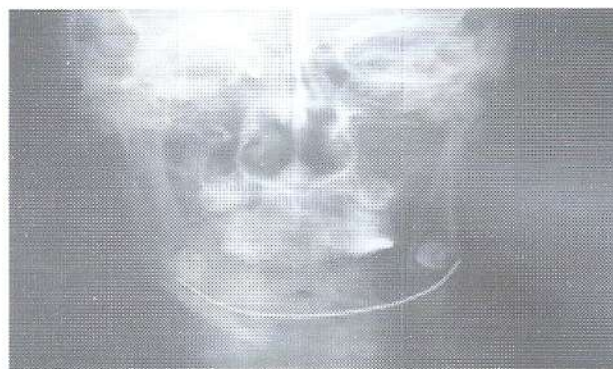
PA radiograph showed the insertion of K-wire
